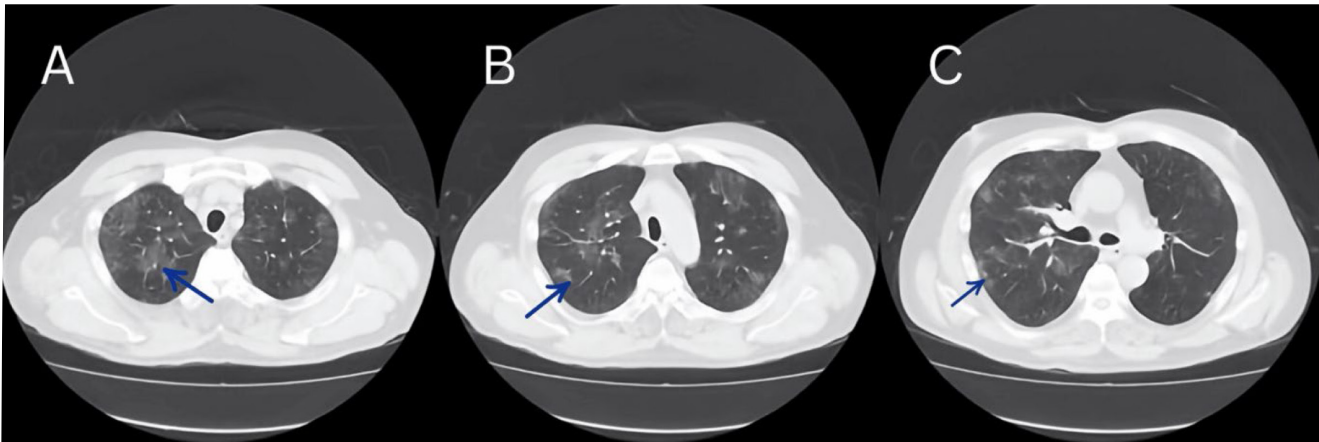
Chest computed tomography (CT) on arrival. Chest CT reveals the presence of ground glass opacity, as indicated by the arrows. ABC in order from pulmonary apex.
